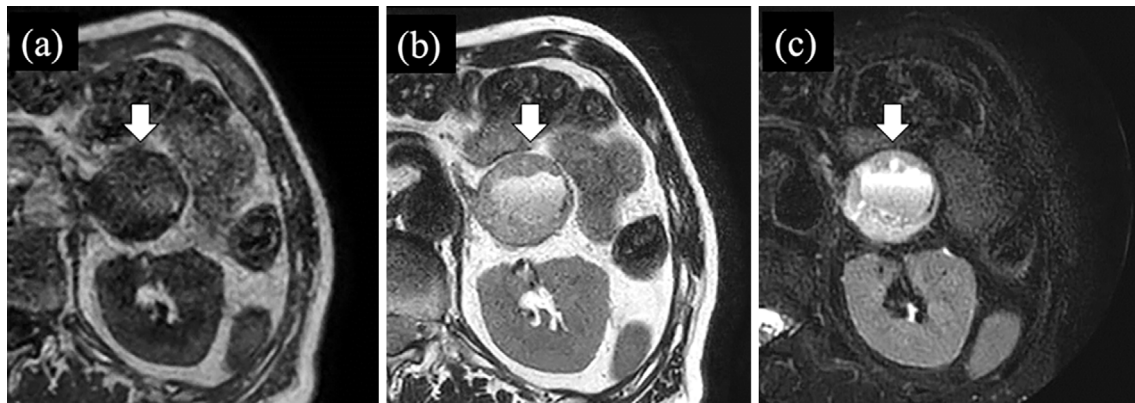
Magnetic resonance imaging (MRI) findings. T1-weighted MRI showed that the mass had low signal intensity. It also contained a faint high-signal area within the mass (arrow) (a). T2-weighted MRI showed that the mass had a relatively high-signal intensity. Inside the mass, there was a region of high-signal intensity with liquid surface formation (arrow) (b). The fat-suppressed T2-weighted MRI showed no change in the internal properties of the tumor compared to the normal T2-weighted MRI (arrow) (c).
